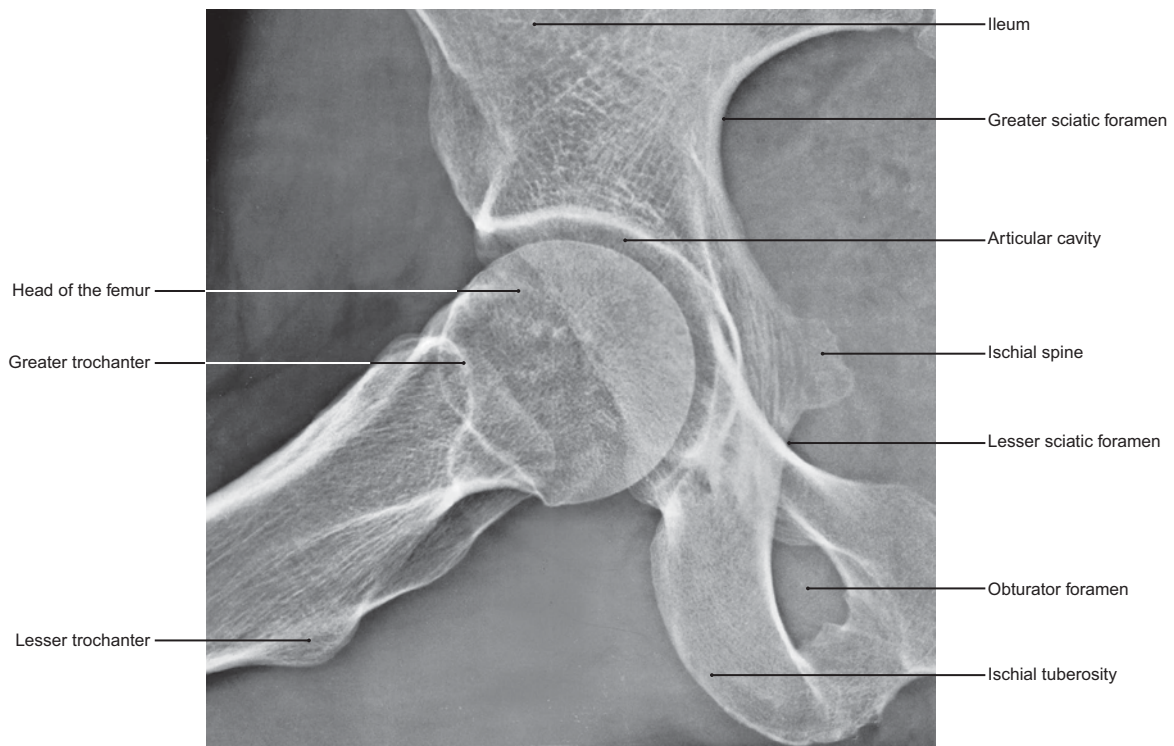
Radiograph of the Hip Joint
